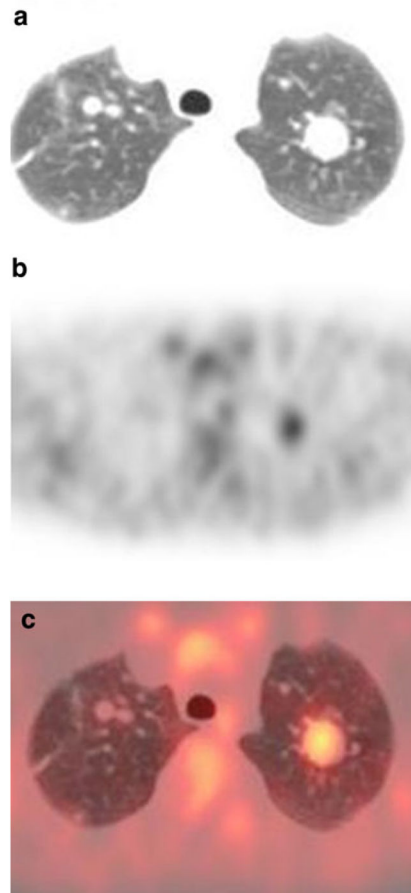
Patient 4: 9-year-old girl with bilateral lung metastases. a Transverse CT image of the lungs (lung window). b FDG PET at same level as a. c Fusion image of a and b. The largest lesion in the left upper lobe shows uptake higher than background lung. Smaller pulmonary lesions in the right upper lobe are not evident on the PET scan
